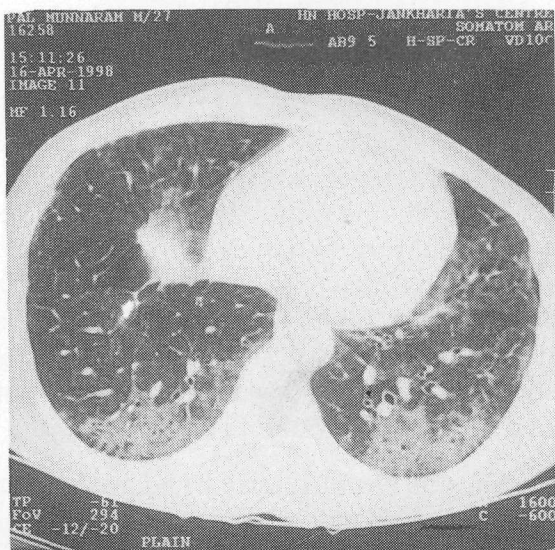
High resolution CT scan shows presence of ground glass pattern in subpleural region in the lower lobes.
